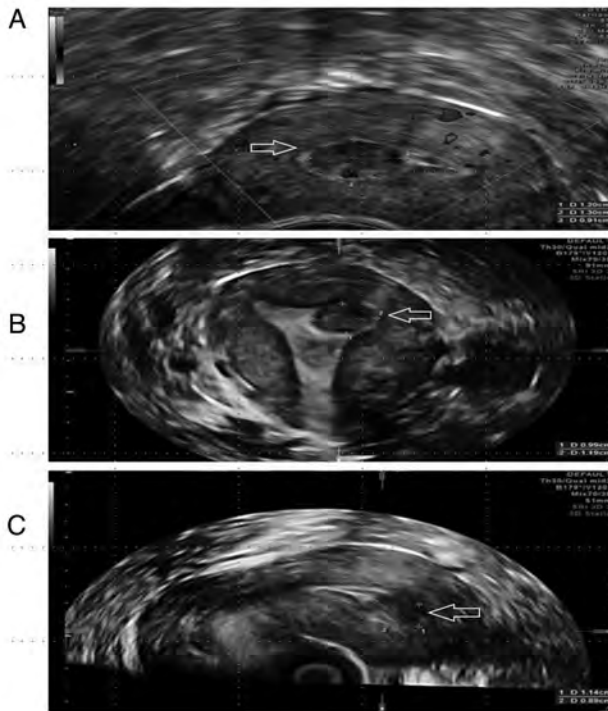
Submucous myoma (arrow). (A) 2D transverse plane of the uterus. (B) 2D ultrasound longitudinal plane of the uterus. (C) 3D ultrasound, coronal plane of the uterus. 2D, two dimensional; 3D, three dimensional.
